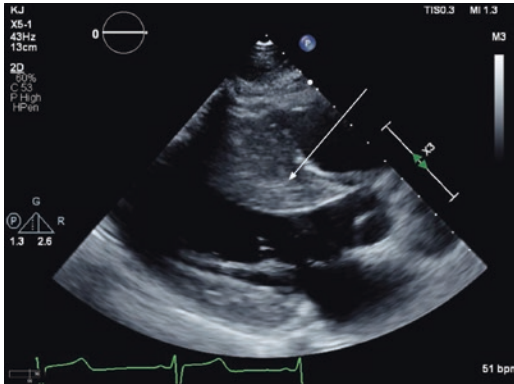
Echocardiography of HCM. Arrow points to asymmetric septal hypertrophy of HCM
